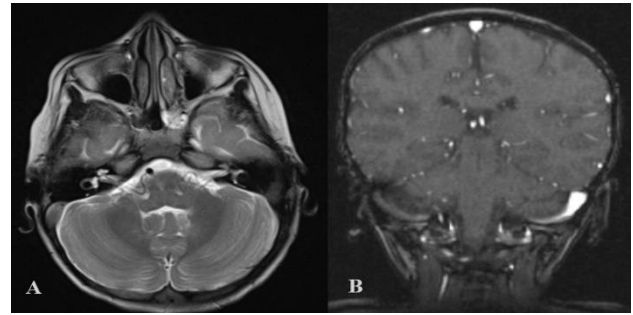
A 5-year-old male patient presenting with vomiting, drowsiness and neck pain. A) T2W axial MR image showing lack of flow void in the right transverse sinus, sigmoid sinus and jugular bulb. B) MRV coronal MR image showing lack of flow related enhancement (thrombosis) in the right transverse sinus, sigmoid sinus and jugular bulb.
